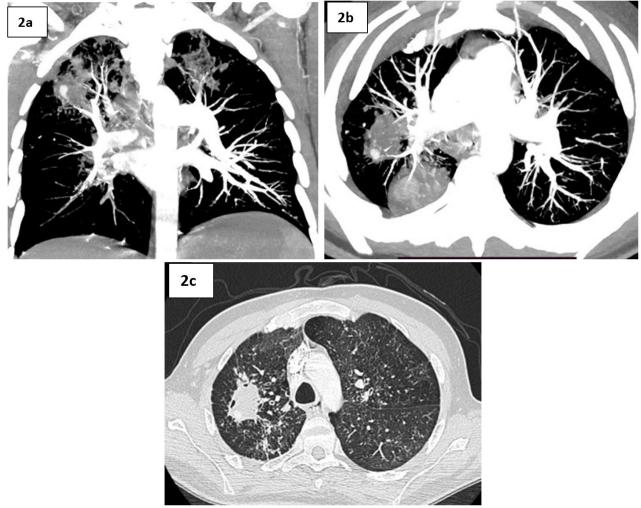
Thoracic CT angiography showing aneurysmal dilatation of a sub-segmental pulmonary arterial branch of the dorsal segment of the right upper lobe in coronal (2a) and axial (2b) sections, adjacent to a tuberculous cavity (2c)
